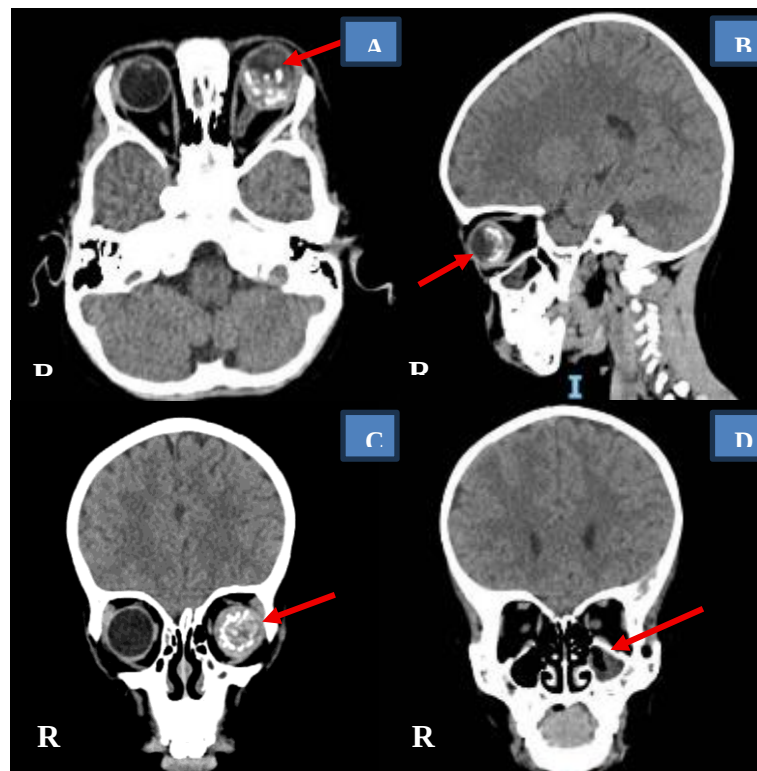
A. Axial Cut – CT, there is a thickening of the irregularity of the left optic nerve, B. Sagittal Cut – CT shows the presence of an intraorbital solid mass, C. Coronal Cut – CT shows the intraorbital period with multifocal calcification, D. Coronal Cut – CT shows thickening of the left maxillary sinus mucosa
